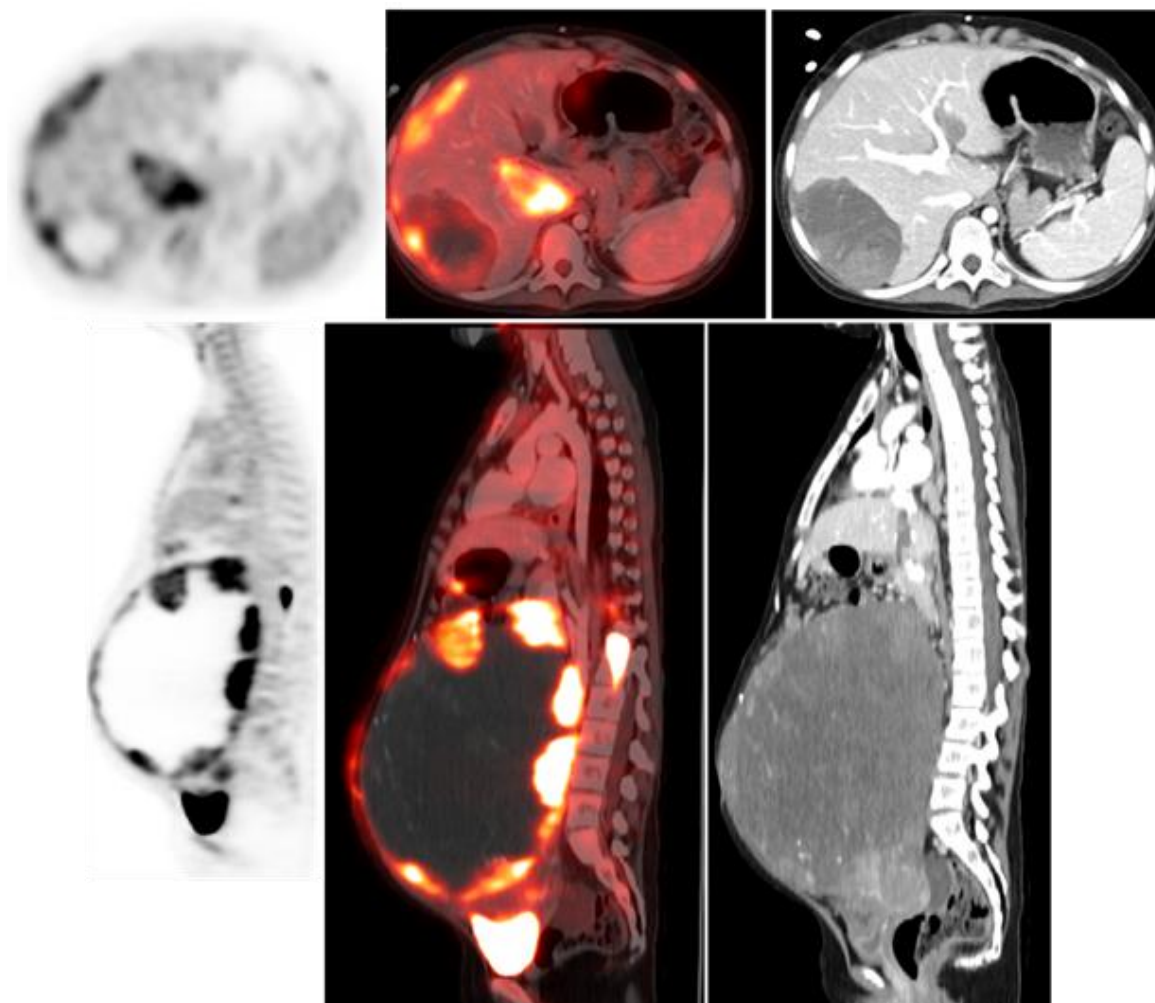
Axial and Sagittal FDG PET/CT showing a large intra-abdominal mass with solid nodular hypermetabolic components: a Rhabdoid tumor metastasis to the abdomen which occurred after primary brain ATRT resection. Unfortunately, the patient ultimately succumbed to the abdominal metastases.
